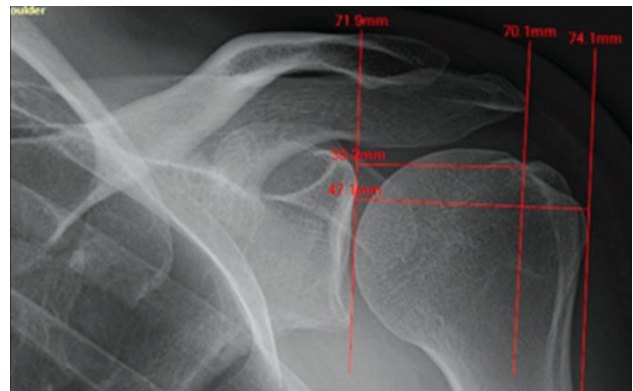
Determination of AI on the AP radiograph of the shoulder joint according to the method described by Nyffeler [7]
